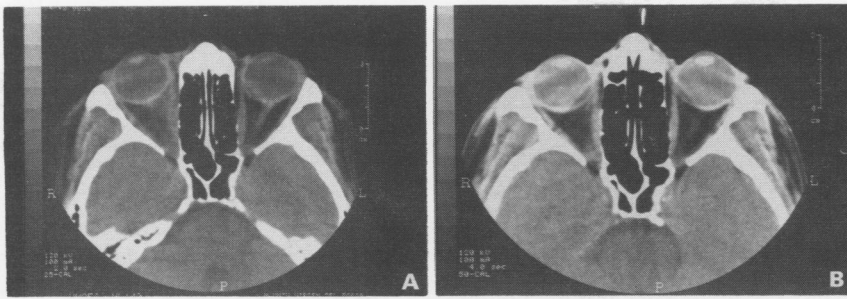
(A) Orbital computed tomography scan showing fusiform enlargement of the right internal rectus muscle. (B) Complete regression of the myositis after cyclosporin treatment.
